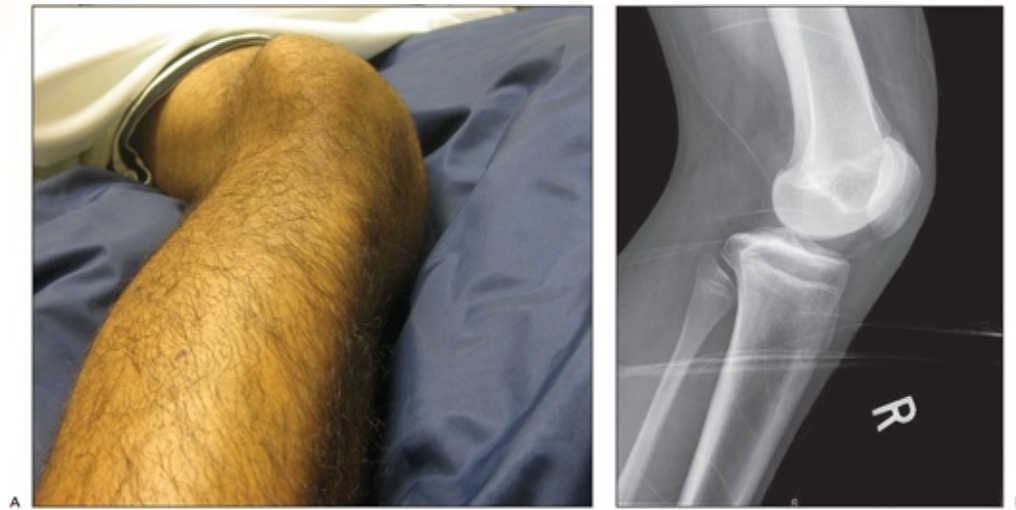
Patella dislocation. A: Clinical photograph. B: Radiograph.
